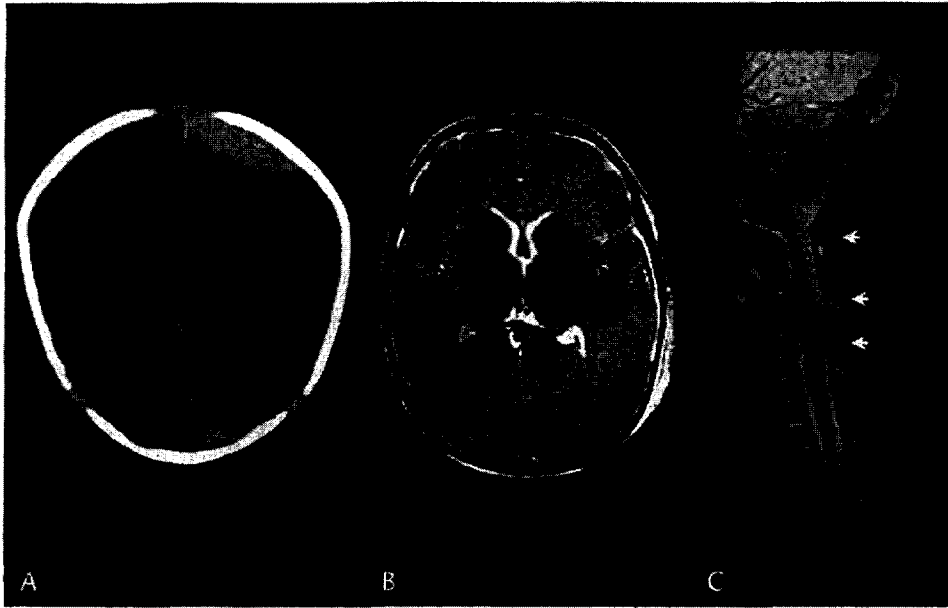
Images obtained from a 25-day-old female neonate with history of drop and RH (alleged NAI). A, Axial CT image shows high-density left-side frontal SDH (surgically drained before MRI), bilateral cerebral low densities with decreased gray-white matter differentiation (hypoxia-ischemia?), and interhemispheric high-density hemorrhage. B, Axial T2 MRI scan shows bilateral cerebral cortical and subcortical T2 high intensities plus interhemispheric T2 low intensities. C, Sagittal STIR cervical spine MRI scan shows posterior ligamentous high intensities (arrows) but no definite cord injury (NAI? SCIWORA?).
